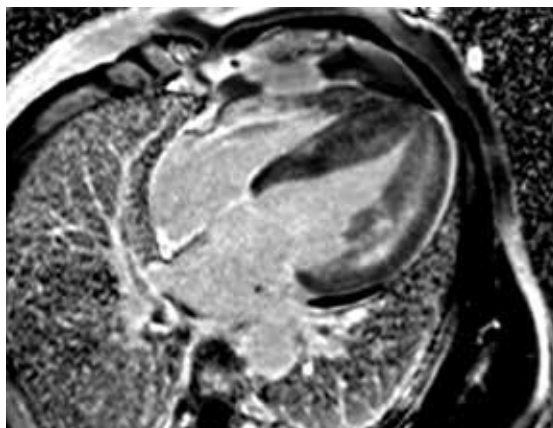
Cardiac magnetic resonance image of presented patient.
